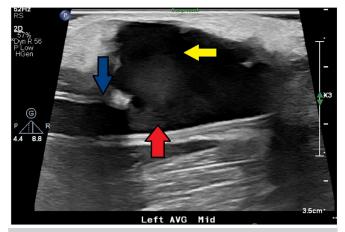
Labeled duplex ultrasound of left upper extremity arteriovenous graft (AVG). *Blue arrow* indicates distal end of intact graft; *red arrow*, ruptured graft segment; and *yellow arrow*, pseudoaneurysm.
